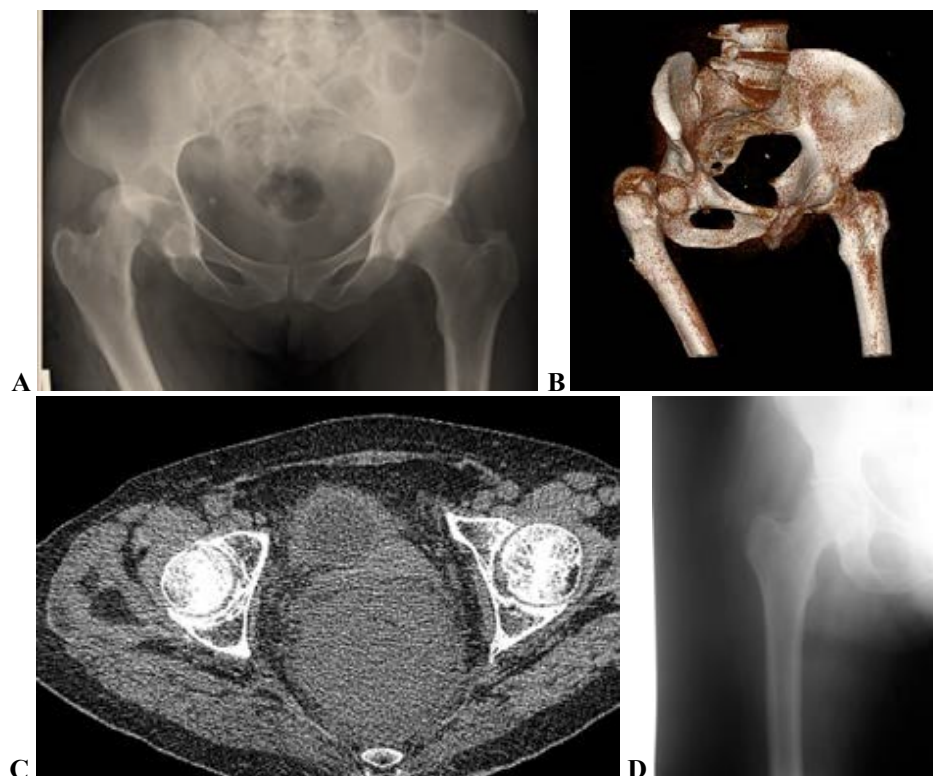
69 years old female patient treated conservatively. Preoperative X-ray (A) and 3D CT (B) showing postero-superior dislocation of the hip associated with a femoral head fracture inferior to fovea centralis (Pipkin type I). Postreduction CT (C) shows anatomical reduction. The patient healed without any complication (D – one year follow-up X-ray).
